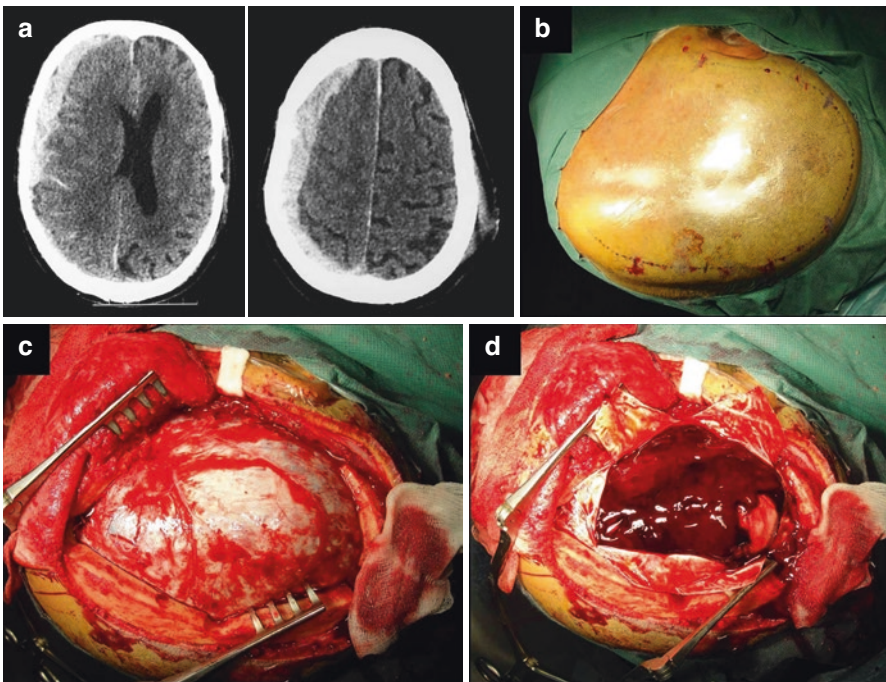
Axial CT scan: post-traumatic acute subdural hematoma on the right side (a). Head position with incision mark (question-mark-shaped) on the scalp (b). Operative view after removing the fronto-parieto-temporal bone flap (c). After opening the dura in a cruciform fashion, the acute hematoma (blood clots) was revealed on the subdural space (d)
